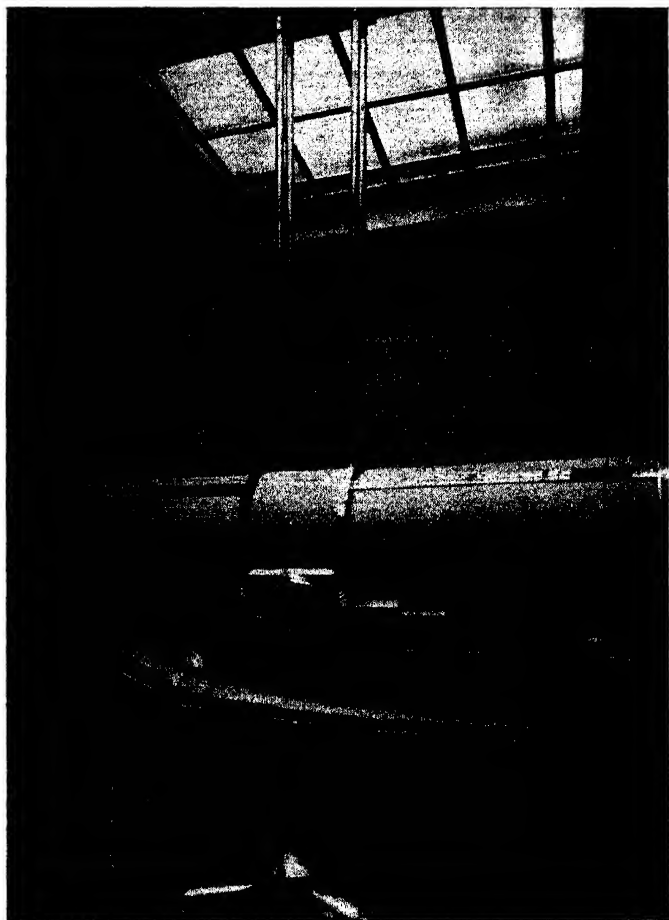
TREATMENT ROOM AND X-RAY TUBE IN THE MOZELLE SASSOON HIGH VOLTAGE DEPARTMENT FOR CANCER AT ST BARTHOLOMEW'S HOSPITAL
